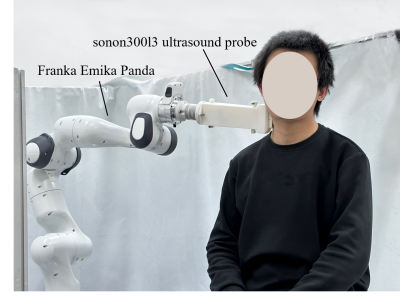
Neck robotic ultrasound imaging platform.
